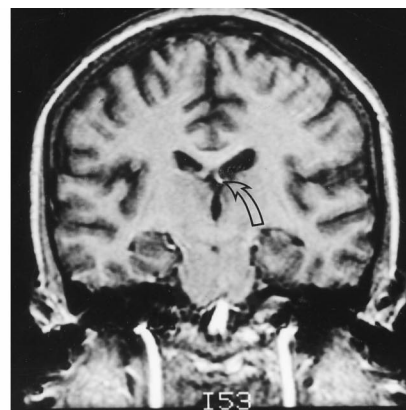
Coronal T1-weighted spoiled gradient-echo sequence (45/5/2) (flip angle, 45°) shows a larger left ventricle and thinner left fornix (arrow) in a patient with right-sided mesial temporal sclerosis.
